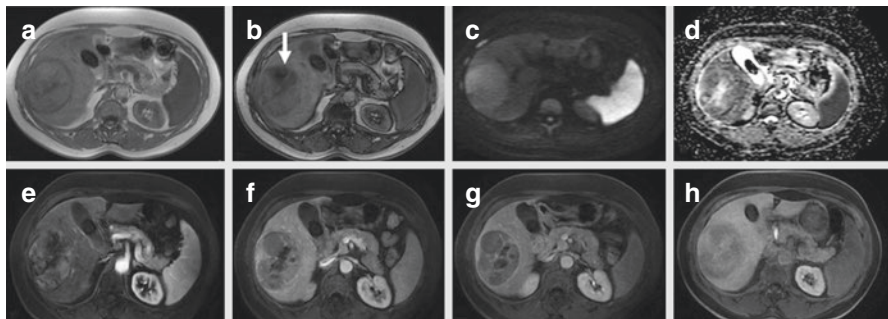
Hepatocellular carcinoma with fat metaplasia at segment 5 and 6. (a) Axial T1-weighted gradient echo (GRE) in-phase sequence where the lesion is heterogeneously isointense to liver parenchyma. (b) Axial T1-weighted GRE out-of-phase sequence with signal drop-out due to intracellular fat component (white arrow). (c) Axial diffusion-weighted images with diffusion restriction of the lesion, (d) also appreciable on apparent diffusion coefficient map. (e-g) After contrast agent administration, the lesion shows slight hyperintensity on the axial T1-weighted fat saturated sequence in the arterial phase (e), with progressive wash-out in the portal venous (f) and delayed (g) phases. (h) Hypointensity of the lesion on axial T1-weighted fat saturated sequence, in the hepatobiliary phase
